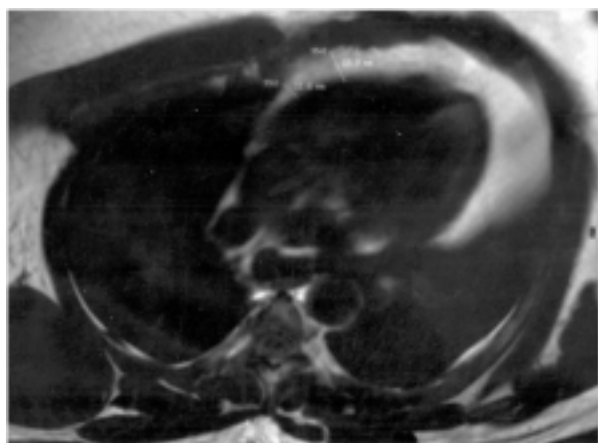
MRI in a patient with visceral obesity. TSET1-weighted sequence with oblique axial orientation for a correct study of the four cardiac chambers, 10 mm thickness section with 1 mm intersection gap, 370 FOV, 256 × 256 matrix.
